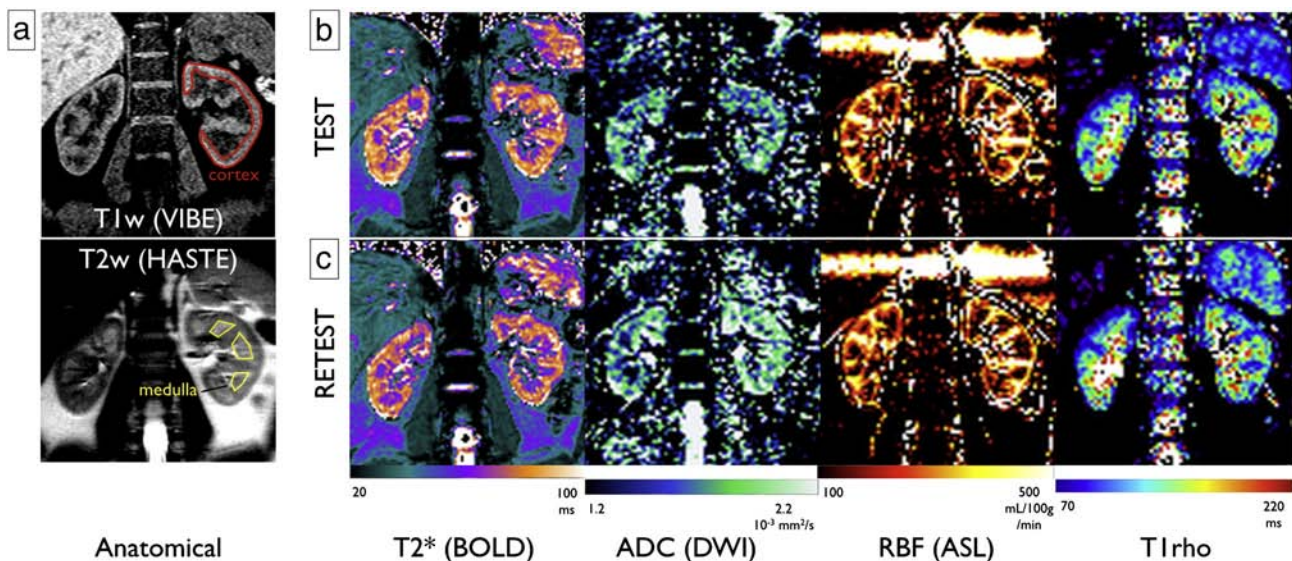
Renal anatomical MRI scans (a), and 4 quantitative MRI modalities with repeated scans (b and c) in a healthy volunteer. Each parameter was quantified on both kidneys using regions-of-interest (ROIs) for both the cortex (red) and the medulla (yellow).
